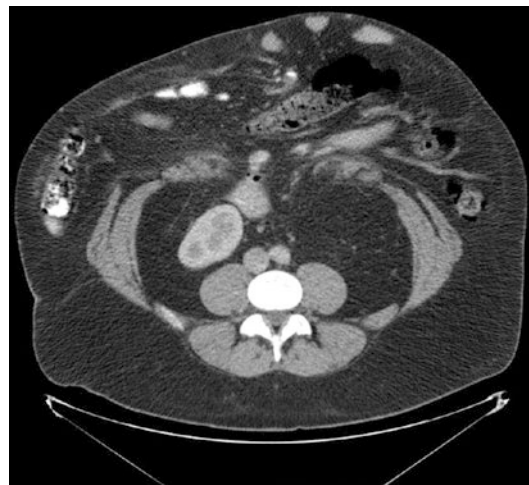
CT axial view of a patient with incisional hernia and loss of domain. Note that more than 50% of the abdominal contents are extra-abdominal and there is a large amount of preperitoneal fat
